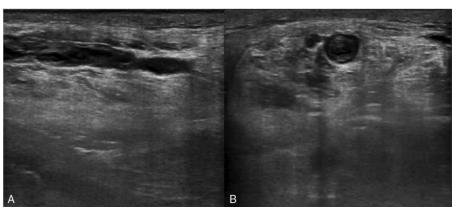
Acute deep vein thrombosis revealed by gray-scale ultrasound. Longitudinal (A) and transverse (B) gray-scale ultrasound images of the gemellar vein demonstrated an enlarged noncompressible vein with intraluminal echoes.
